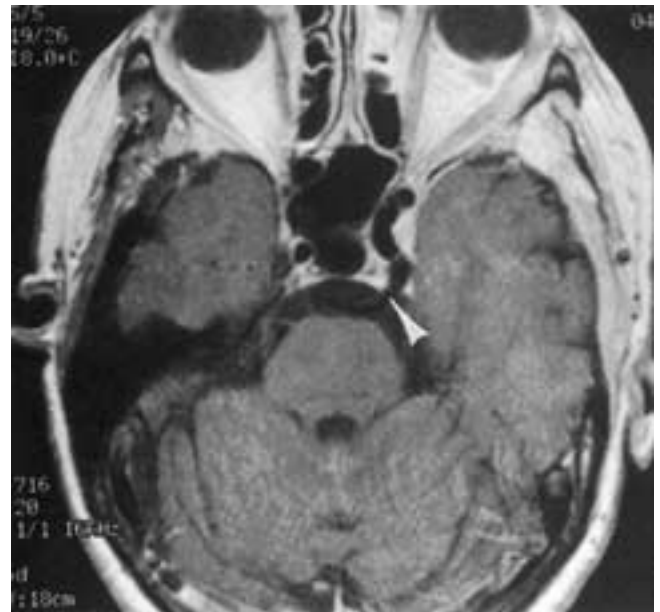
Persistent trigeminal artery. The postcontrast T1-weighted MR image shows the flow void connecting the intracavernous carotid artery with the basilar artery. *Arrowhead*, trigeminal artery.
